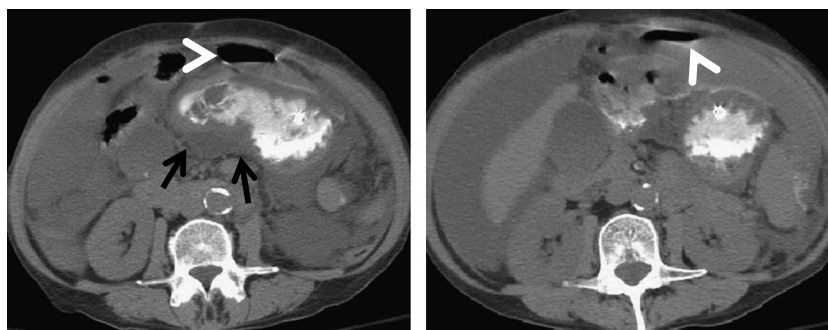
Gastric perforation in a 39-year-old woman secondary to gastric ulcer. Axial CT images of the abdomen after oral contrast administration show diffuse wall thickening of the antropyloric region of the stomach (arrows) with perigastric free intraperitoneal air (arrowheads) suggestive of gastric perforation.
